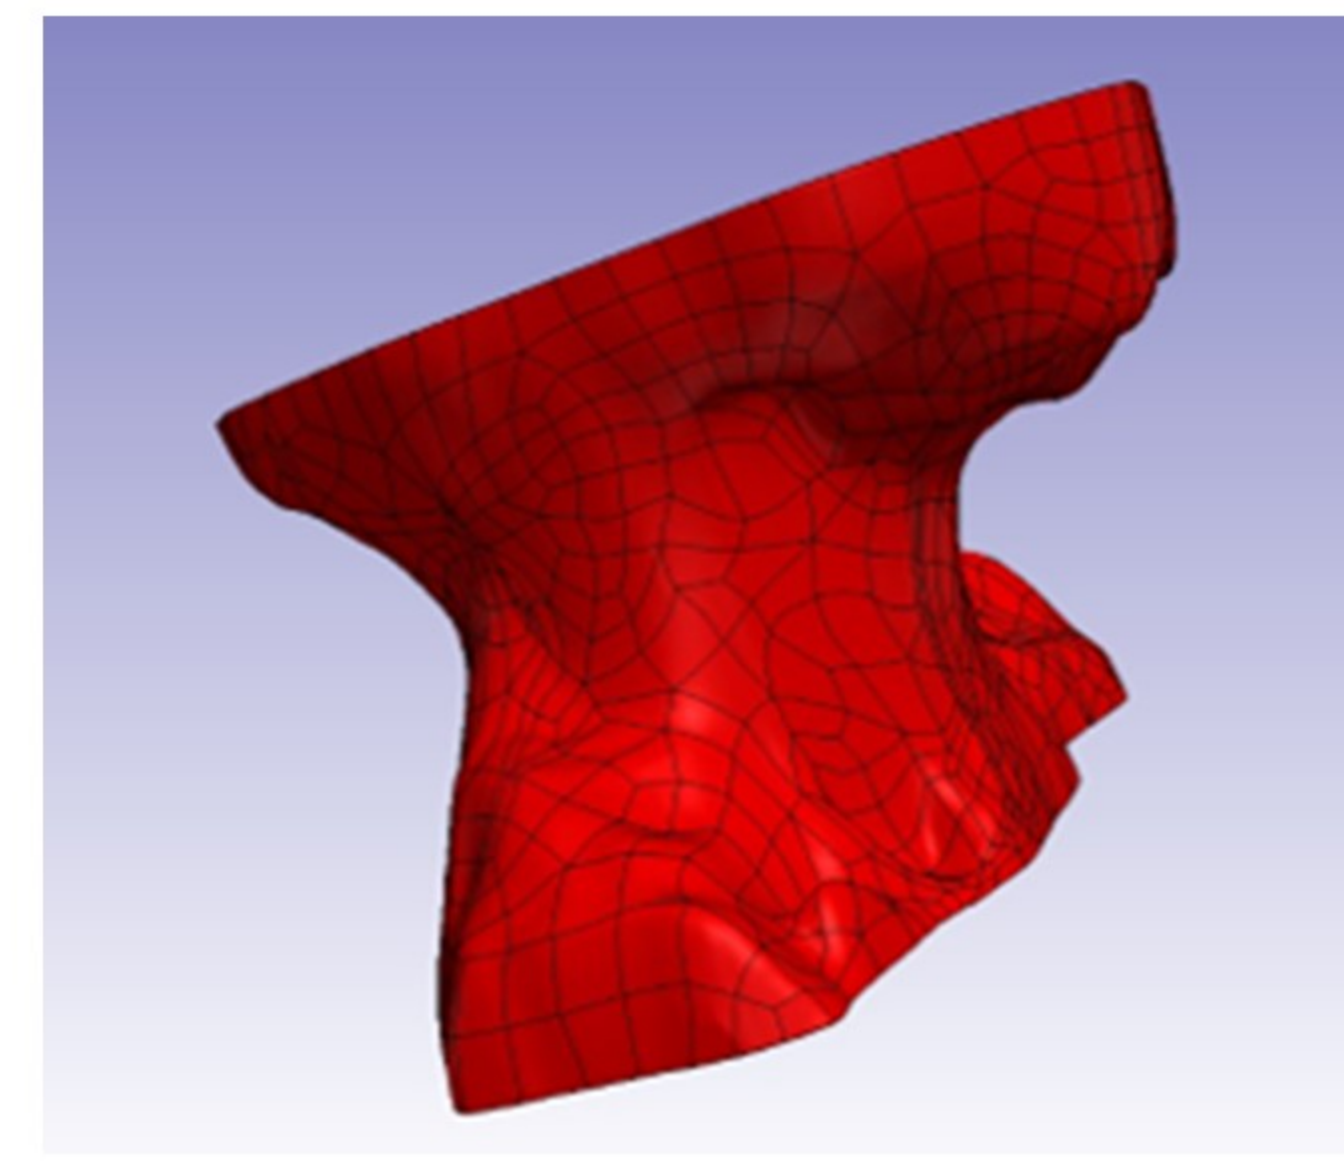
Computer-aided design model of neck surface topology generated from a CT scan
